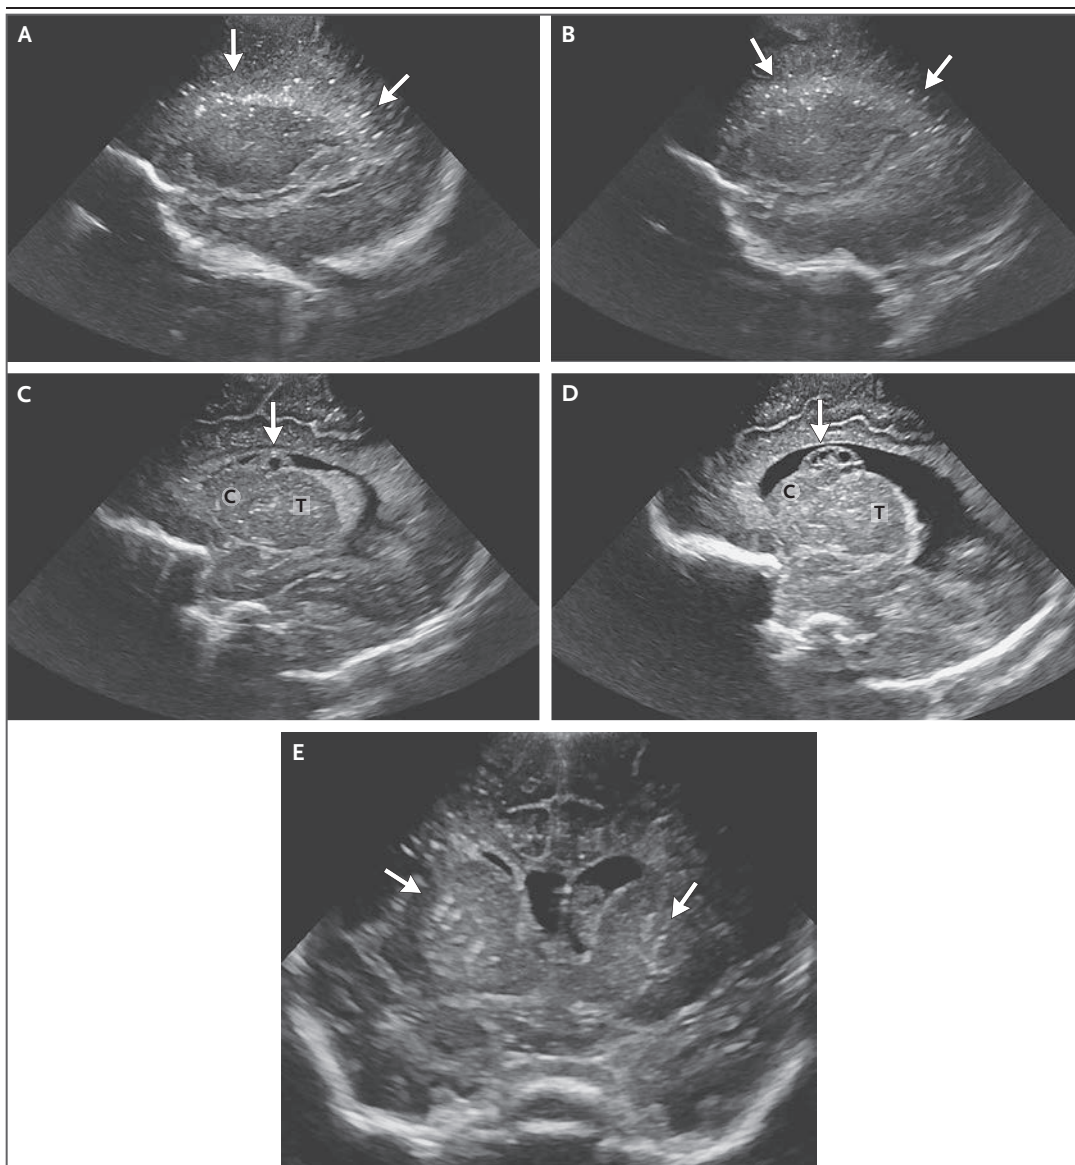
Cranial Ultrasound Images.
